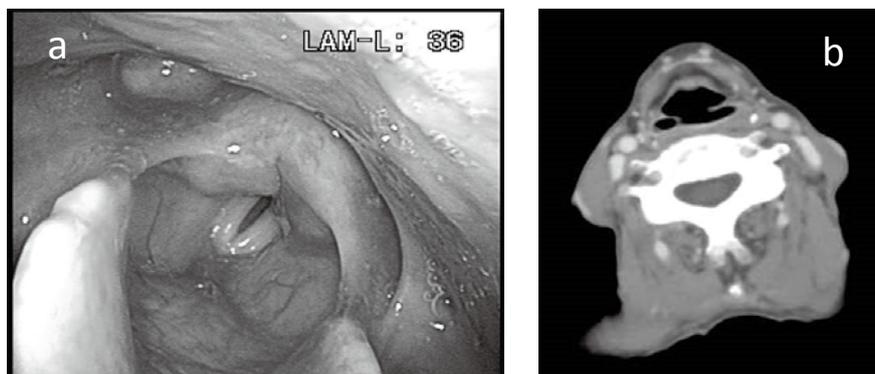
The hypopharyngeal fiberscope (a) only reveals slight scarring of the hypopharyngeal mucosa and enhanced CT (b) reveals slight mucosal thickening after steroid treatment.
